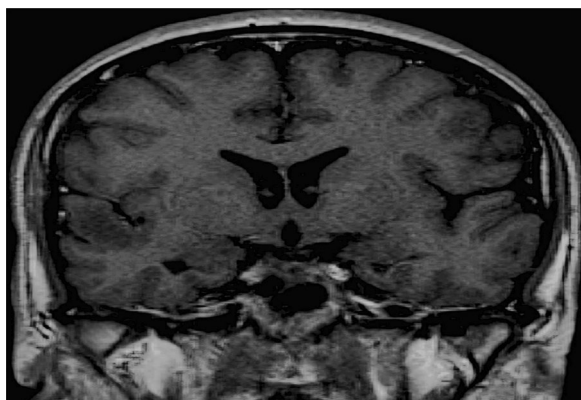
Magnetic resonance imaging (MRI) T1-weighted image of the brain post-contrast revealing a small high-intensity lesion in the right temporal lobe
